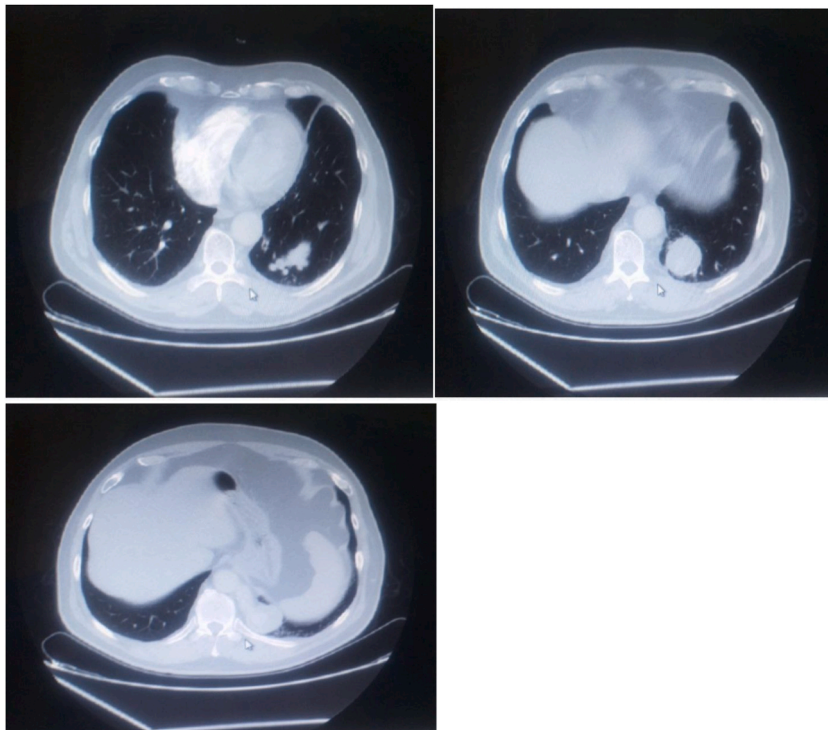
A CT scan showing the anomalous segmental lung tissue in the left lower lobe.
